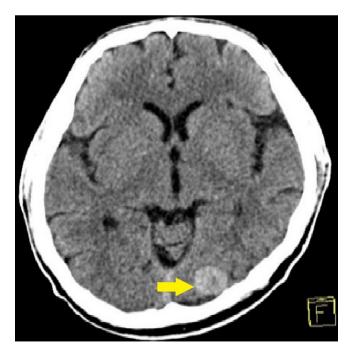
A contrast-enhanced cranial CT scan showing a $2.0 \times 1.7 \times 1.6$ cm hyperdense focus on the left occipital lobe (as pointed by an arrow).
